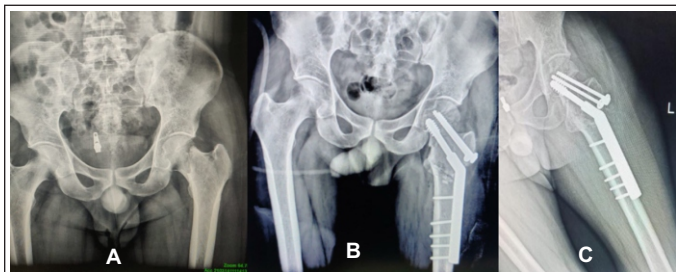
A. Showing pre op Pelvis X-ray with vertical oriented femur neck fracture B. Immediate post op X-ray and C. Follow up X-ray showing union at fracture site and osteotomy site.
